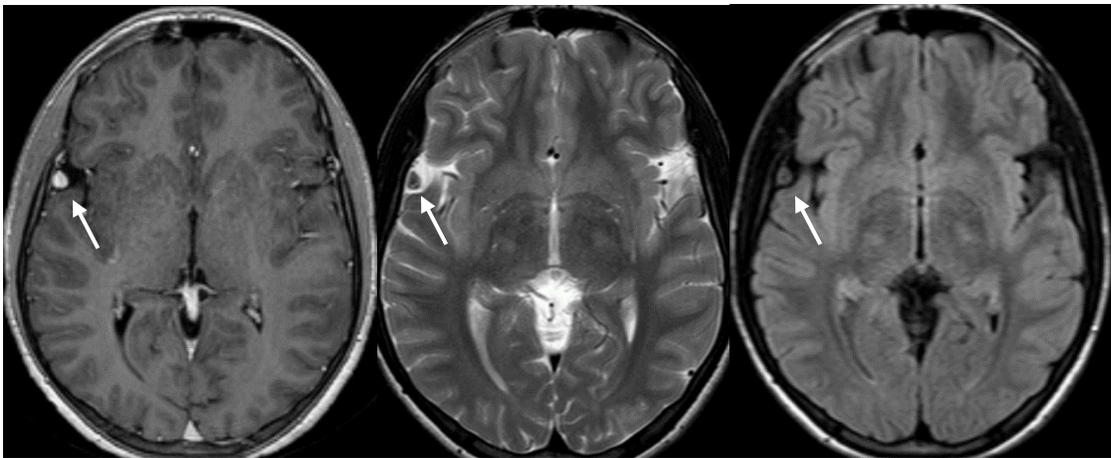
Last MRI in 2025 showing the right Sylvian millimetric vascular lesion naturally regressed at 6mm
